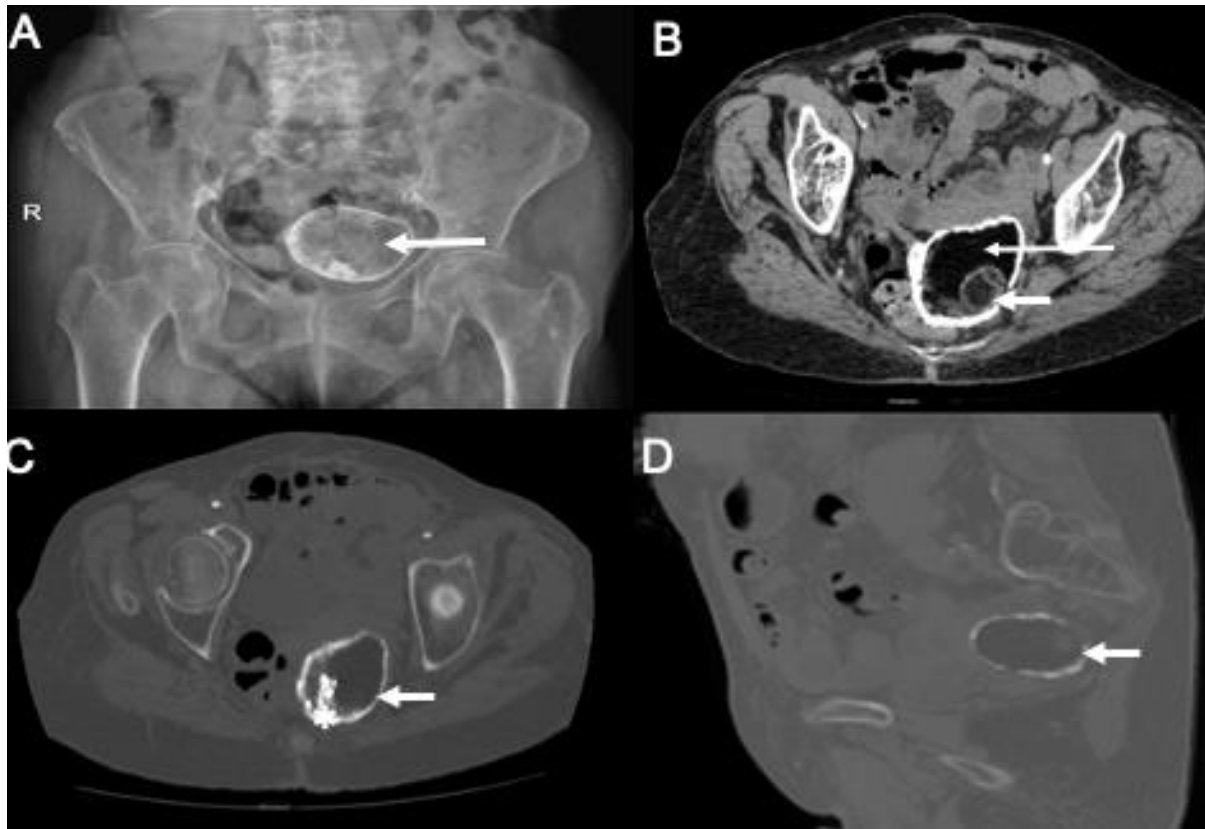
MCT on a pelvic radiograph (A) was performed due to trauma. Further evaluation with CT in soft-tissue (B) and Bone (C, D) windows shows the calcification of the wall (short arrow), the fat component (long arrow), and a tooth (asterisk).
